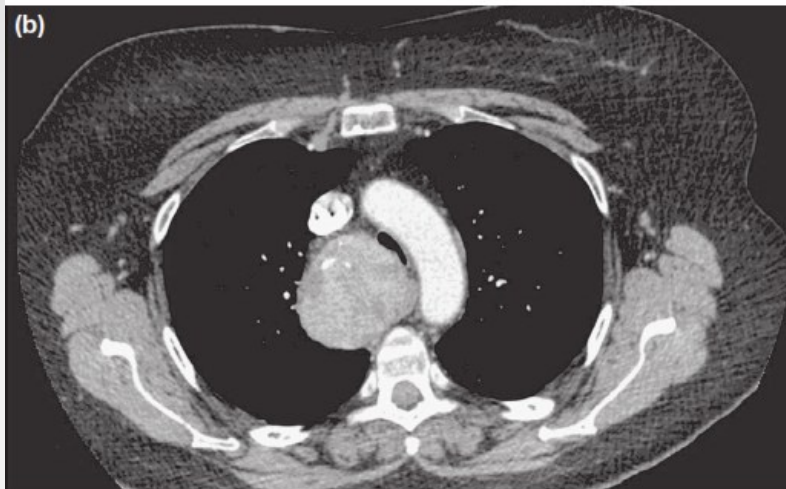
(a) Scout film showing retrosternal goitre. (b) Axial computed tomography (CT) section showing goitre extending to below the aortic arch with tracheal compression. (c) Coronal CT section showing goitre extending to the tracheal bifurcation. (d) Sagittal CT section showing goitre filling the posterior mediastinum.
